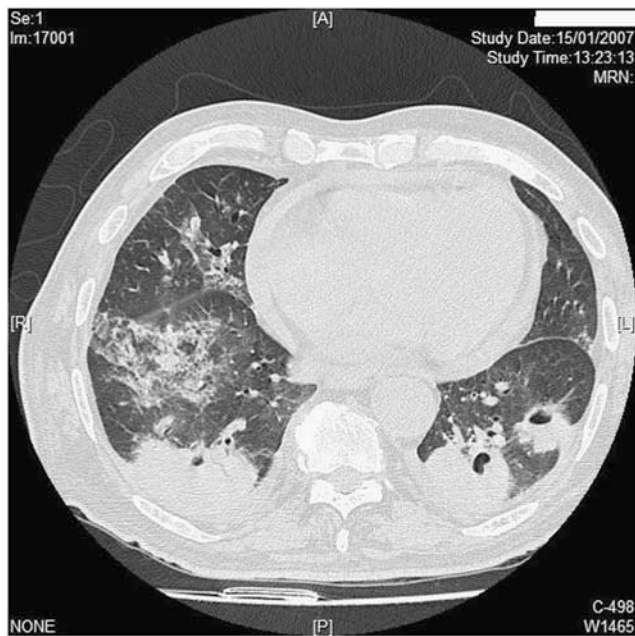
Chest CT scan showing pulmonary interstitial-alveolar infiltrates and multiple cavitations.
